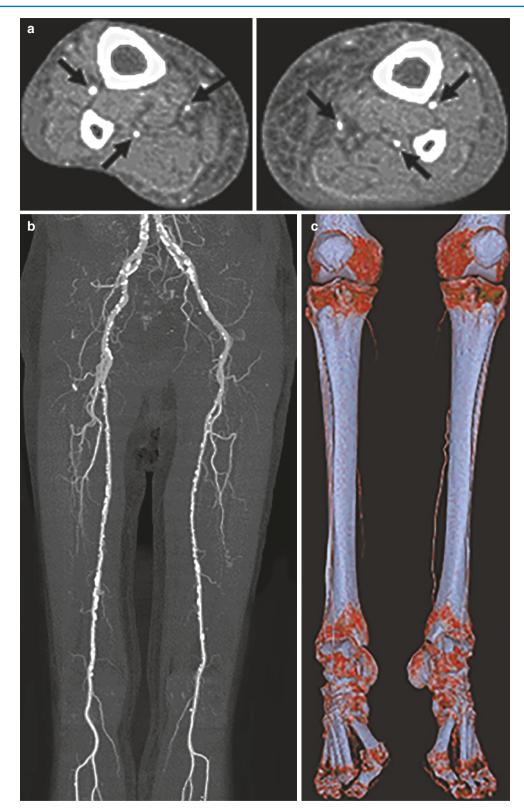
CT angiogram with patent vessels in woman with concern for claudication. (a) Axial image of both lower extremities from a CT angiogram represents the source image for subsequent computer generated post-processed images. All three lower extremity run-off vessels are patent bilaterally, seen as small bright foci (arrows), due to administered contrast. (b) Maximum intensity projection (MIP) image was generated in the image processing lab from a stack of source images similar to (a) acquired through the lower body. The MIP mimics a conventional arteriographic display. Bilateral three vessel run off (proximal
